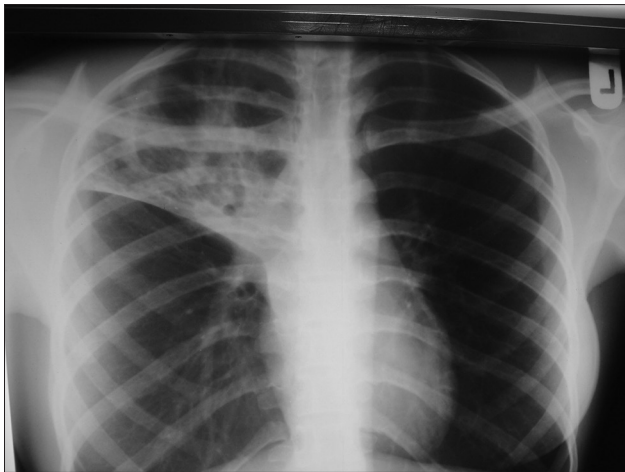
PA chest radiograph of HIV/PTB on HAART patient showing a fairly homogenous opacity with background cavitary changes in the right upper zone bounded inferiorly by elevated transverse fissure. There is obliteration of the right mediastinal outline
